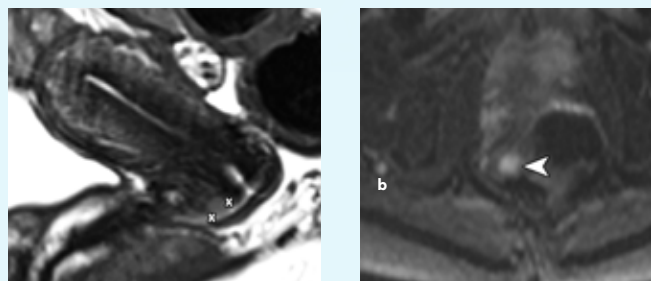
a. Sagittal T2-w MRI scan in a 23-year-old woman showing a lesion of intermediate signal (between callipers) measuring 1.4cm in diameter in the anterior lip of the cervix consistent with Stage IB1. Transverse diffusion weighted imaging (DWI) scan (b) and ADC map (c) showing a lesion (arrowheads) with high signal on b with low signal (diffusion restriction) on c.
